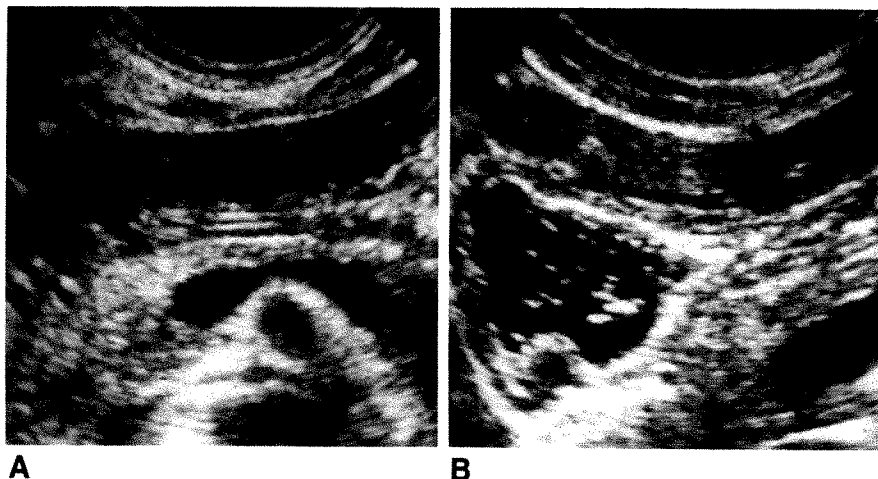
Sonograms show gastric fluid in fasting patient.
